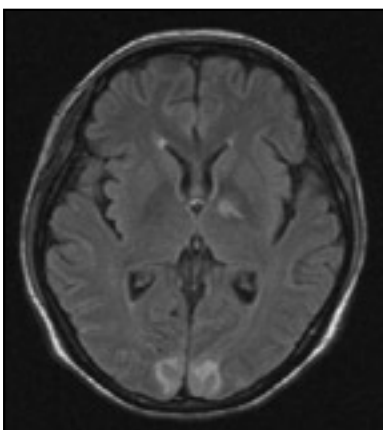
Axial FLAIR (fluid attenuated inversion recovery) image showing bilateral T2 hyperintense lesions at the parieto-occipital region of brain. There was a similar lesion in the anterior aspect of the left thalamus
